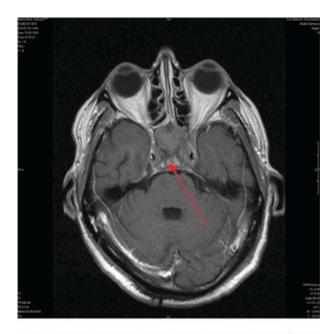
Magnetic resonance imaging scan showing hyperintense tumour of the clivus.
